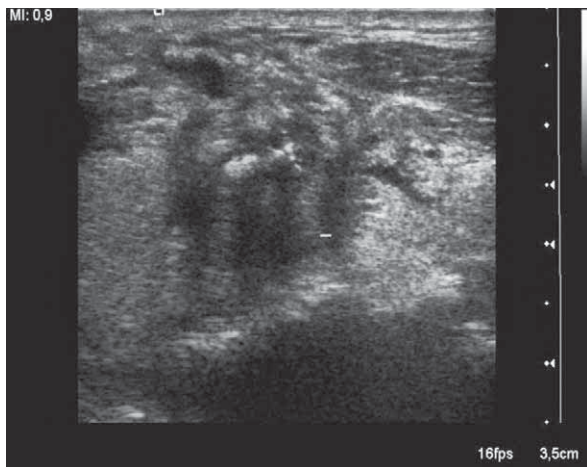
Axial ultrasound picture presenting dilated oesophagus below a TE prosthesis after forced phonation as a sign of proximal spasm.
